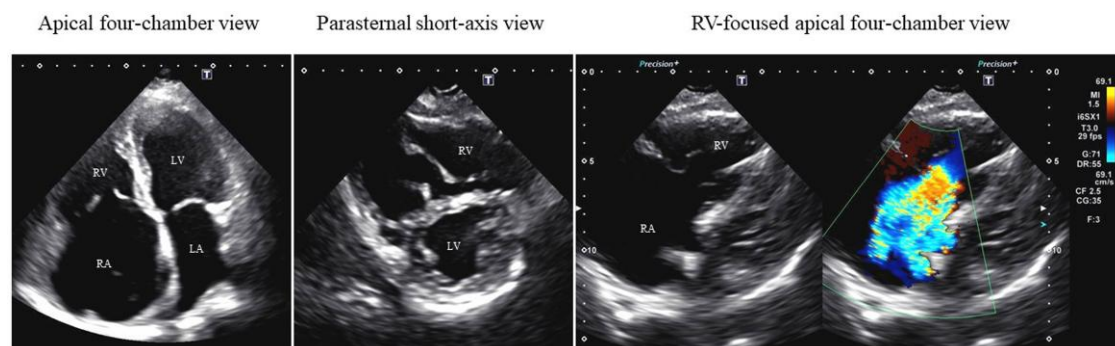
Transthoracic echocardiography at second admission, showing progression of right ventricular and right atrial dilatation, and functional tricuspid regurgitation.
